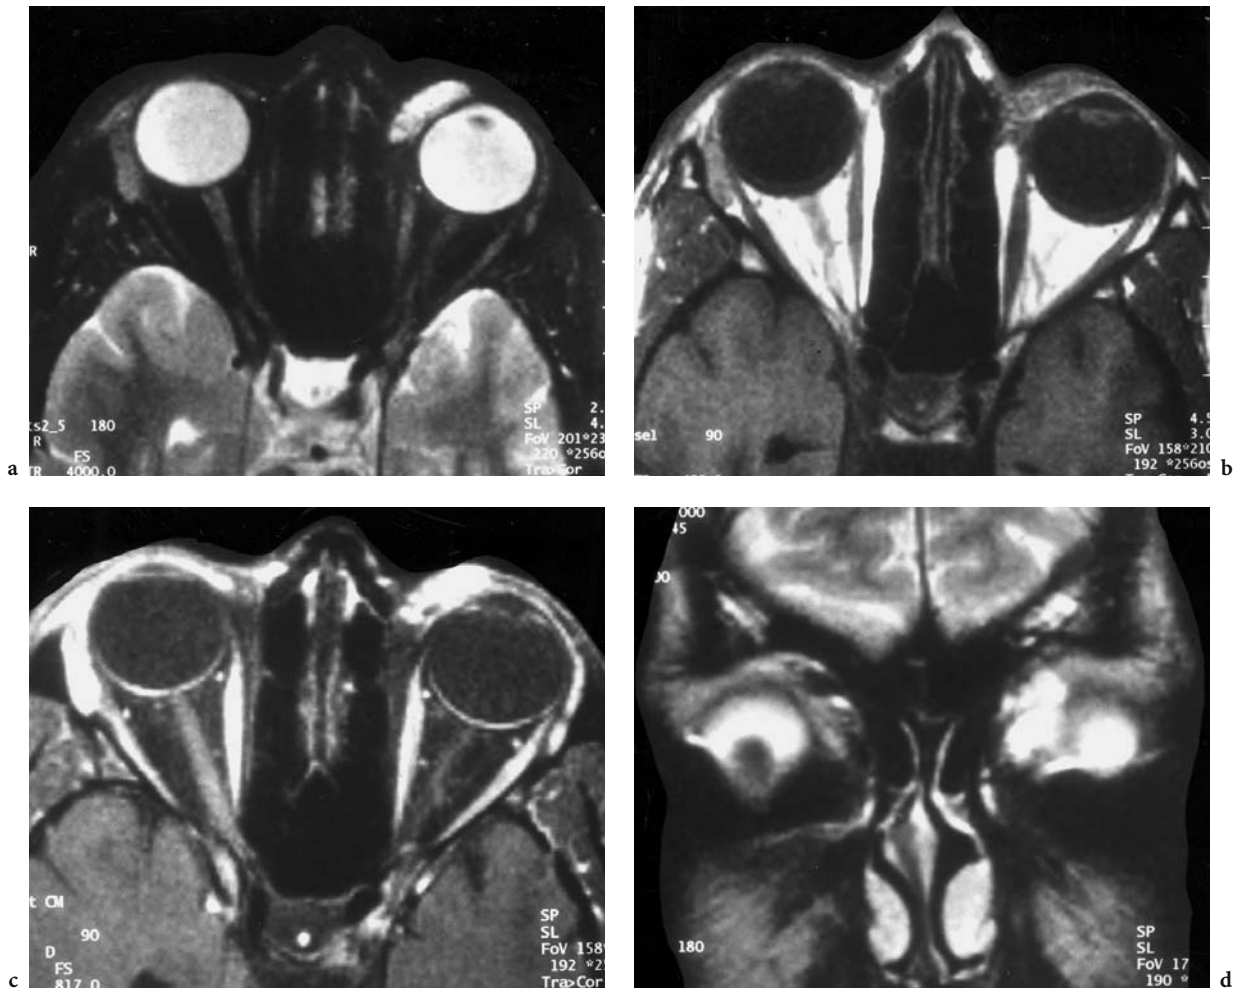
A 21-year-old woman with slowly progressing tumor of the right inferior lid. Diagnosis: hemangioma (primarily extraconal). MRI: a Axial T2-weighted view of the medial orbit showing a medially located hyperintense preseptal ovoid lesion. b Corresponding T1-weighted native view where a hypointense, well-defined formation in front of the medial rectus muscle and globe is seen. c Corresponding T1-weighted (FS), contrast-enhanced view with bright signal enhancement. d Coronal T2-weighted view with bright signal enhancement visualizing the predominantly extraconal localization of the hyperintense tumor in the superior medial orbit
